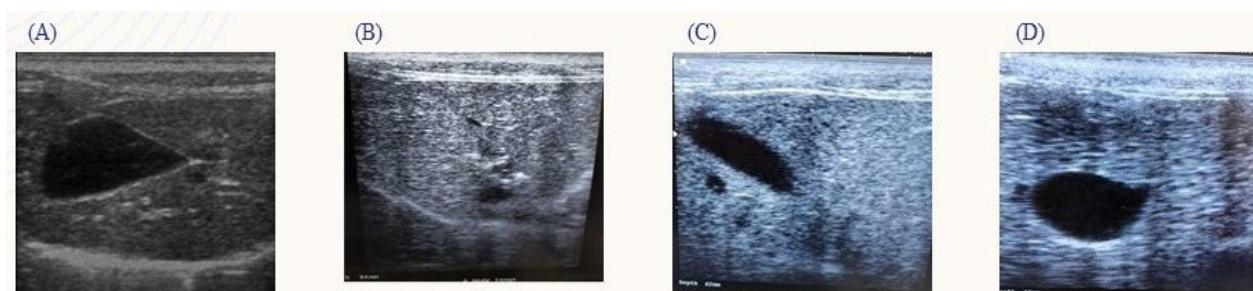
A) Normal sagittal scan of the liver parenchyma that appeared homogenous moderately echoic interrupted by anechoic gall bladder (GB) and short, highly echogenic paired parallel lines that represent the portal veins (PV) at day 0. B) Liver ultrasonography on day 7 of dexamethasone injection notice uniformly increase in echogenicity of hepatic parenchyma (appeared nearly equivalent). C) Liver ultrasonography on day 14 of dexamethasone injection notice uniformly moderate increase in hepatic parenchyma with necrotic foci. D) Liver ultrasonography on day 21 of dexamethasone treatment notice uniformly marked increase in hepatic echogenicity.
